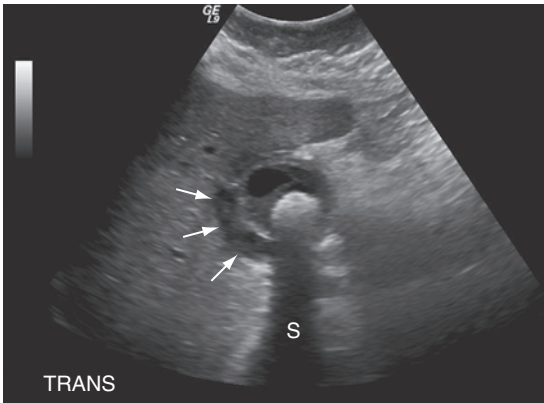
Perforated cholecystitis. A transverse sonogram in a patient with acute cholecystitis demonstrates free fluid (arrows) consistent with perforation. A large gallstone with acoustic shadowing (S) is also present.
